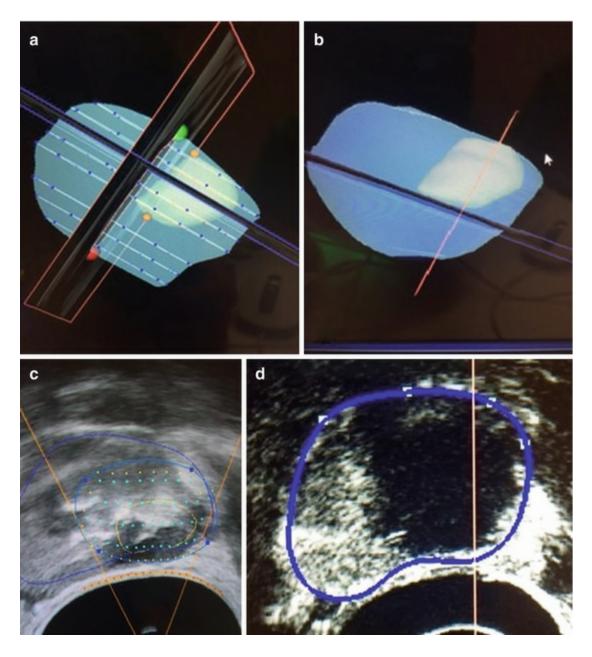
(a) Imported MR Image with ROIs (b) Image fusion after elastic transformation (c) Focal one treatment planning (d) contrast-enhanced ultrasound (CEUS) of the treated area
